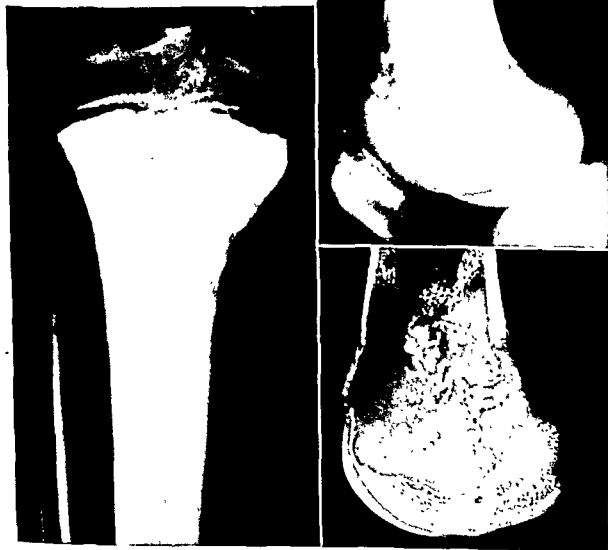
(Left) Roentgenograph of a highly ossified osteogenic sarcoma that still is confined largely within the bone, though the cortex on the medial side is being destroyed because of some penetration of the tumor outward from the bone. (Right, top) Roentgenograph of an osteogenic sarcoma that is producing only little tumor osteoid and tumor bone. (Right, bottom) Roentgenograph of a thin slice of the lesion shown above. This slice demonstrates far better than the clinical roentgenograph the ossification taking place within the tumor.
